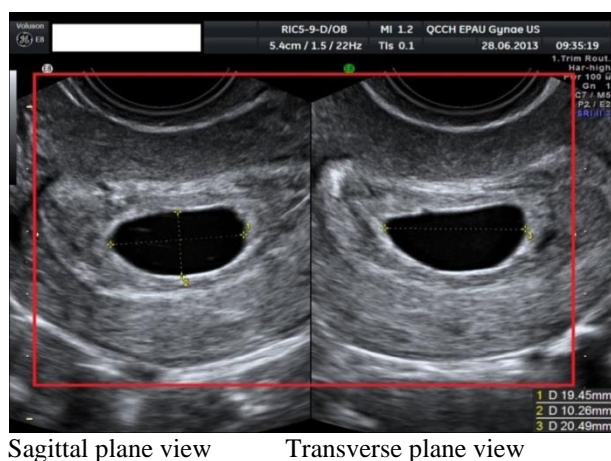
23: Ultrasound image of GS in Sagittal and Transverse planes
